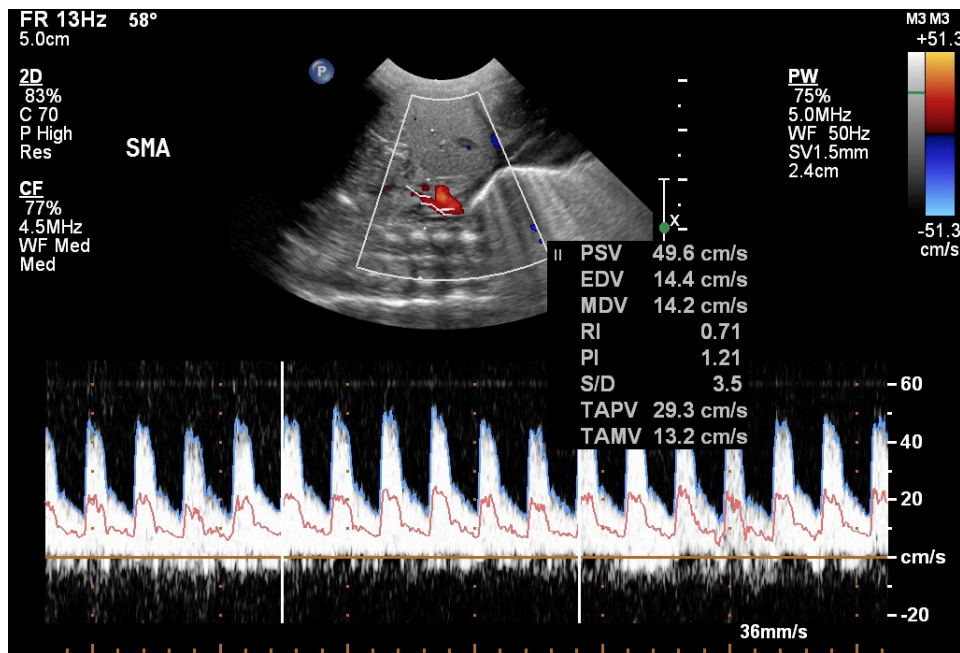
Longitudinal view of the superior mesenteric artery with the Doppler sampling gate placed in the artery. The time averaged mean velocity was calculated from 6 artefact free waveforms.
